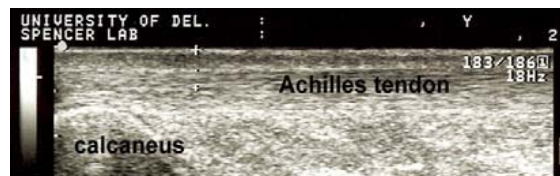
Sonogram with Achilles tendon.
